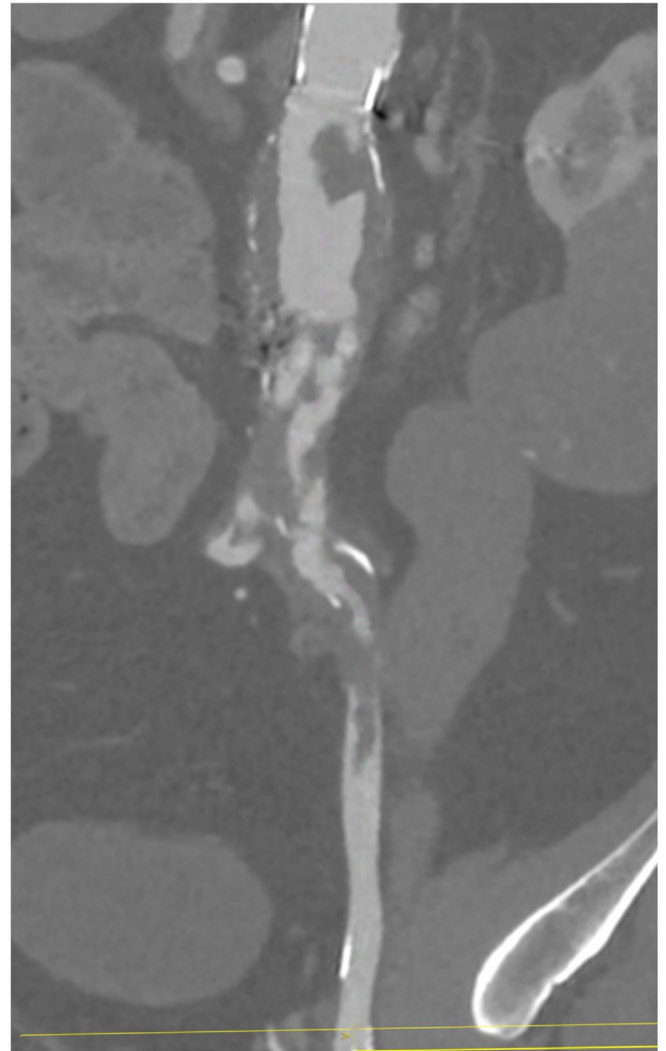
Reconstructed computed tomography angiography image showing extent of tumor in the aorta and left iliac limb.
